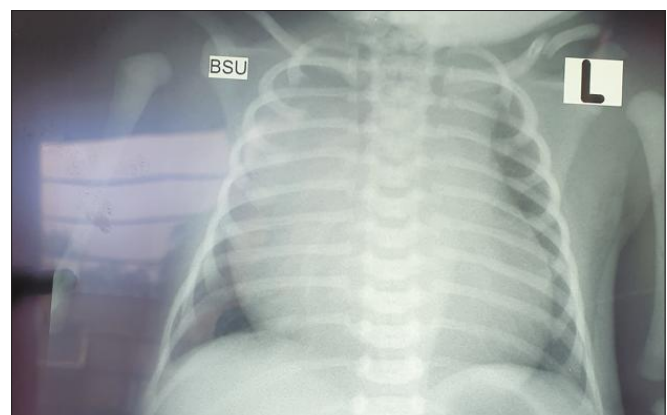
Chest X-ray showing cardiomegaly and left clavicular fracture.
